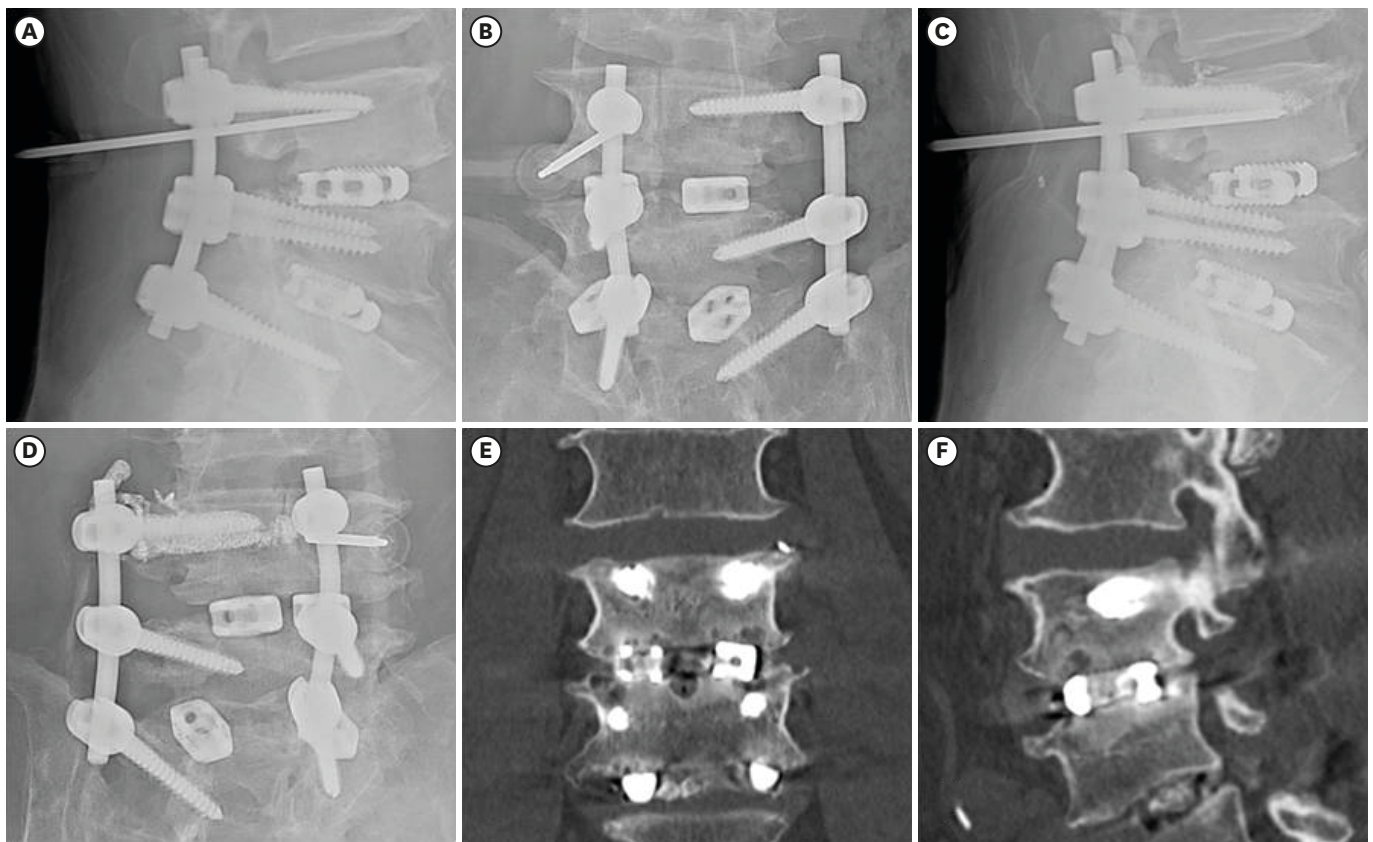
A 70-year-old man who underwent posterior lumbar interbody fusion at L3–4 and L4–5 developed halo formation in the lower part of the screw at L3. (A, B) Antibiotic-loaded cement augmentation was performed by inserting a needle under the screw on the right side. (C, D) The same procedure was performed by inserting the needle under the screw on the left side. (E, F) Coronal and sagittal computed tomography scans taken after the procedure show satisfactory filling of cement.
